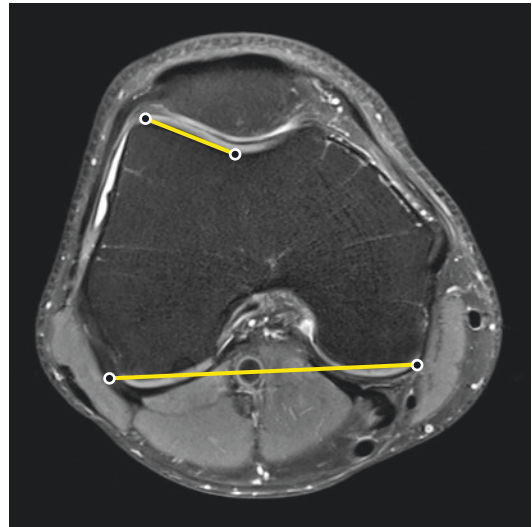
Measurement of lateral trochlear inclination on an axial MR image of the knee at the most superior level that demonstrates trochlear cartilage
